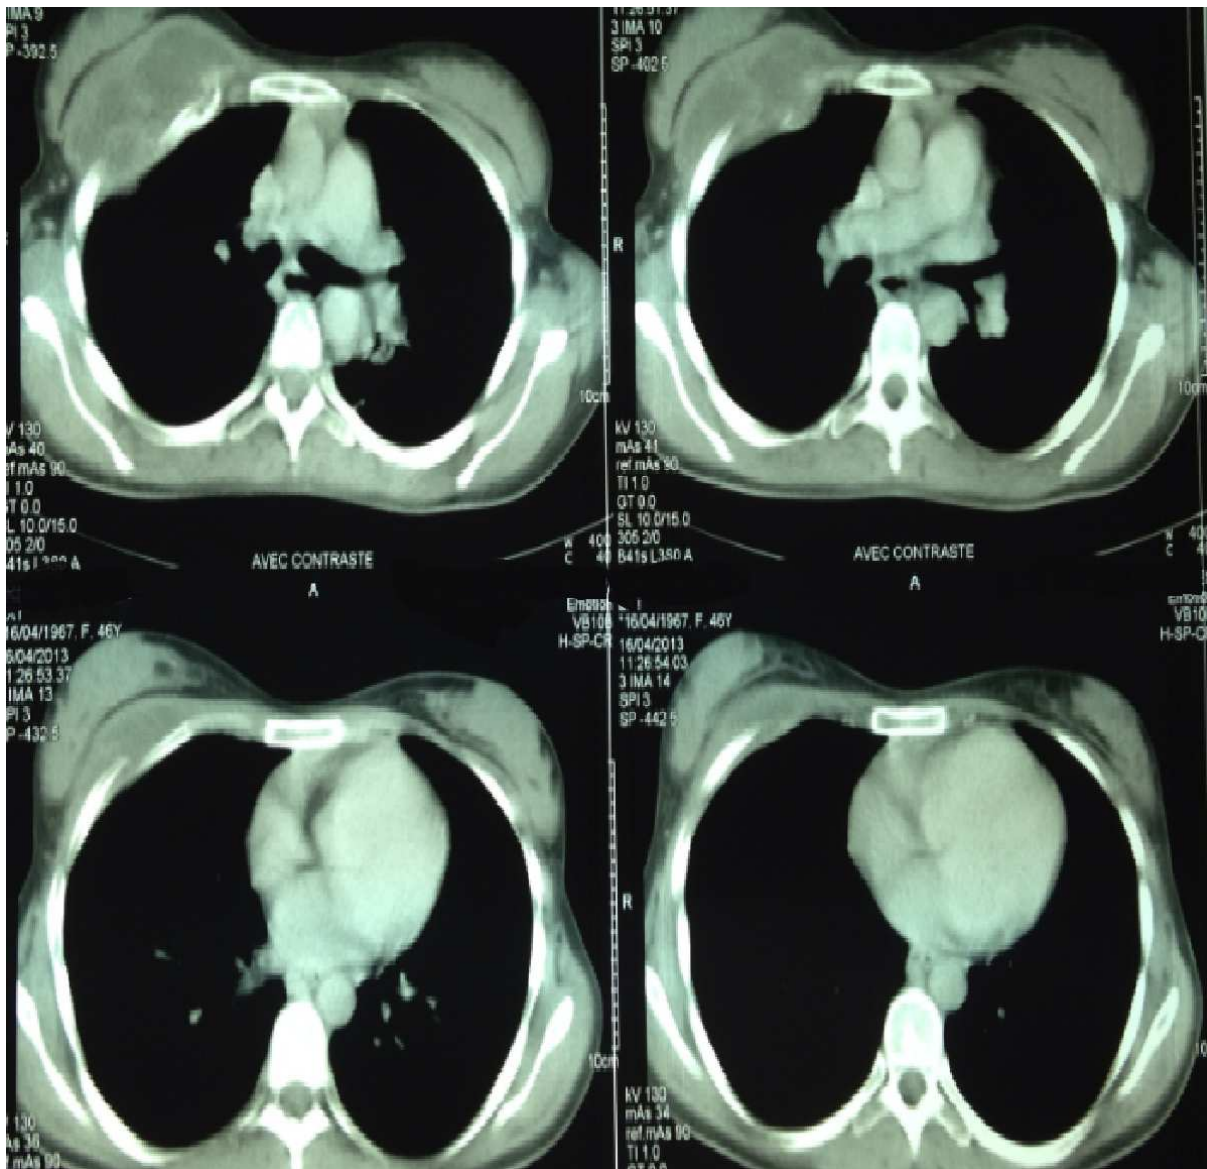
chest CT showing a heterogeneous mass in the right breast density.
